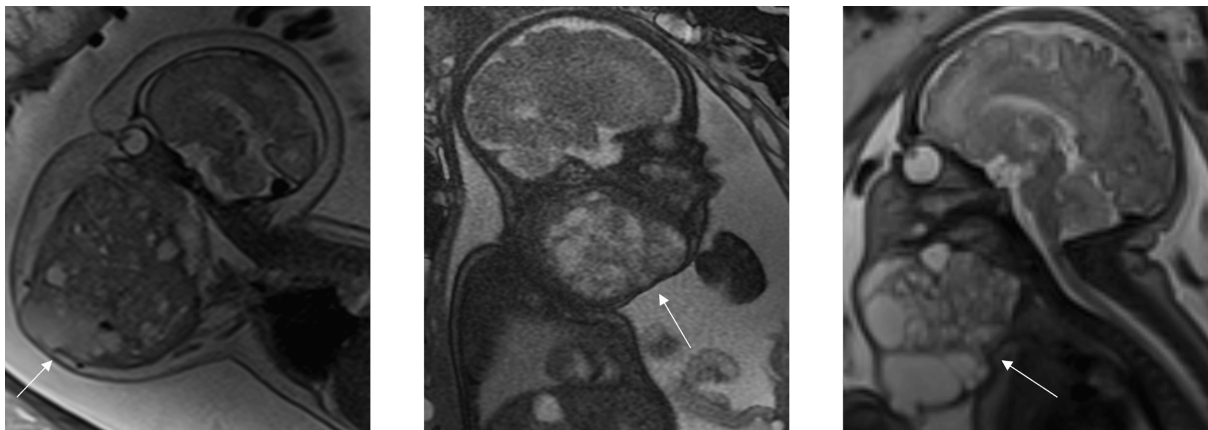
Fetal MRI images of teratoma
